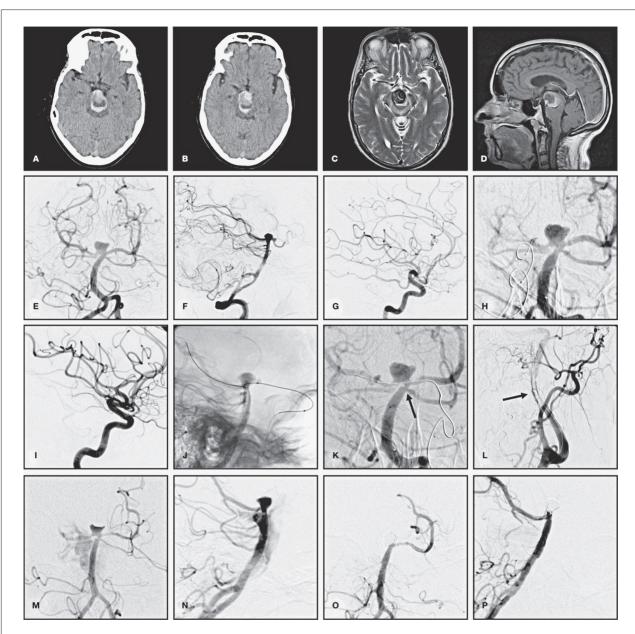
Case 1. CT (A,B) and MR (C,D) scans showed a giant, partially thrombosed basilar bifurcation aneurysm, with mural hematoma. E,F) Left vertebral angiography shows a small, broad-based patent residuum. G,H) Retrograde catheterization through the right posterior communicating artery was unsuccessful. I,J) Catheterization through the smaller left posterior communication artery allowed crossing of the basilar bifurcation but the wire was advanced far into the choroidal artery arising from the right posterior cerebral artery (J). K) The wire could no longer be retrieved without causing traction with deformation of the P1 basilar tip junction. When the guiding catheter was retrieved from the left internal carotid artery, where it had caused spasm and occlusion (L), the right posterior choroidal artery along with a segment of P1 were avulsed, with severe extravasation (M,N). O,P) The hemorrhage was controlled by coiling of the aneurysm and basilar apex.
